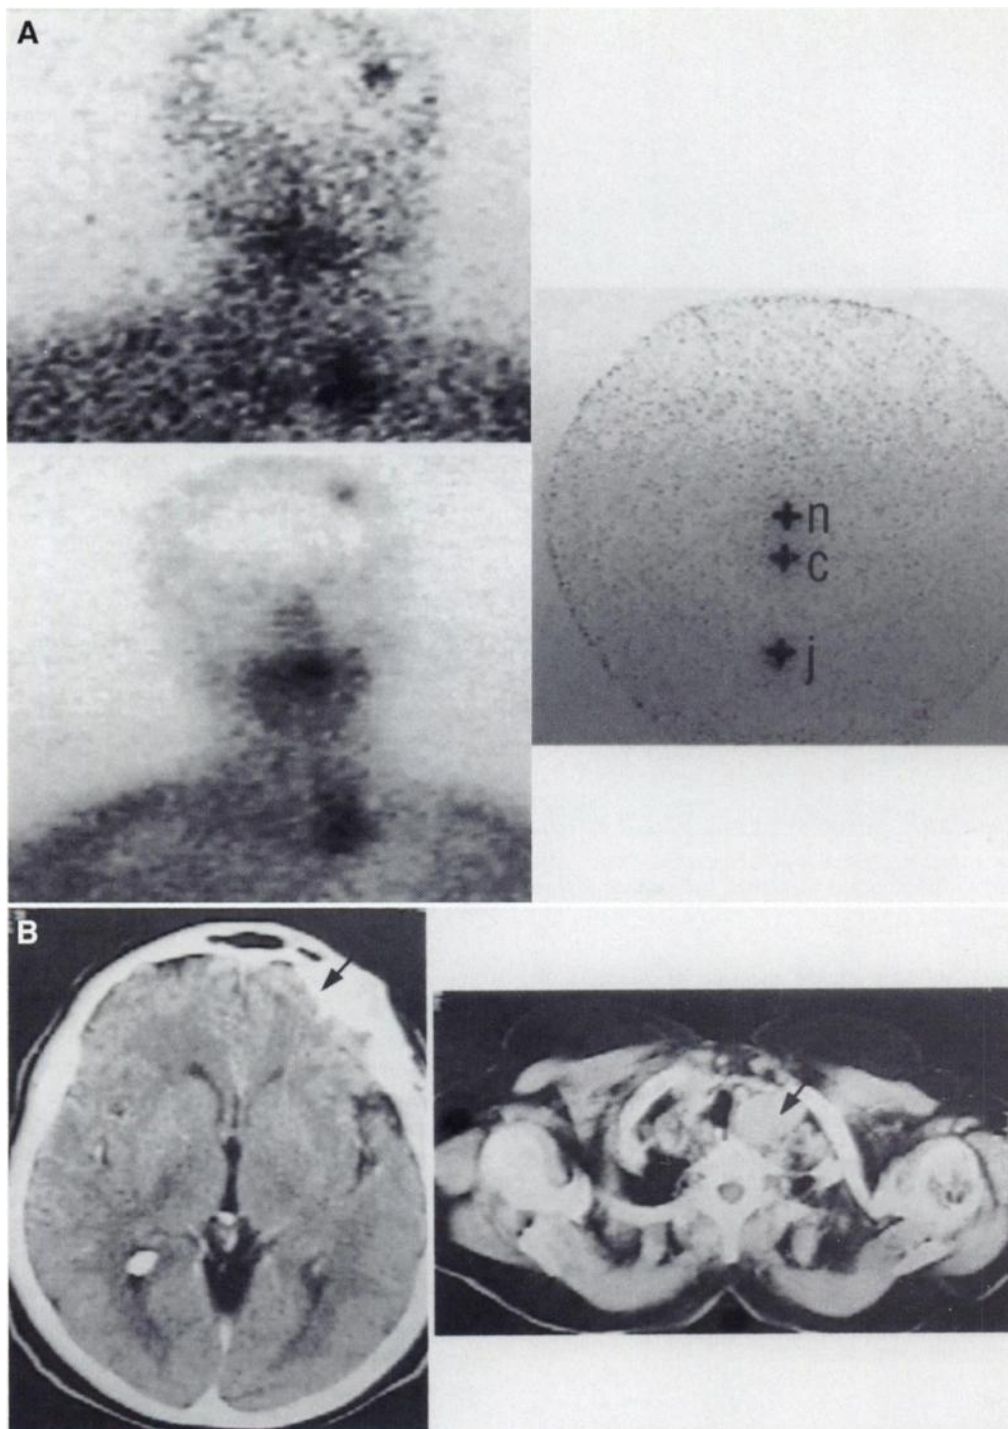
(A) Anterior ^{201}Tl (left upper) and $^{99\text{m}}\text{Tc}$ -tetrofosmin (left lower) images show increased uptake in left frontal and left upper mediastinal regions. These regions showed no detectable ^{131}I (right) uptake. N = nose; C = chin; J = jugular (suprasternal) notch. (B) Corresponding CT scans show lesions in left frontal bone (left) and left mediastinal lymph nodes (right).
